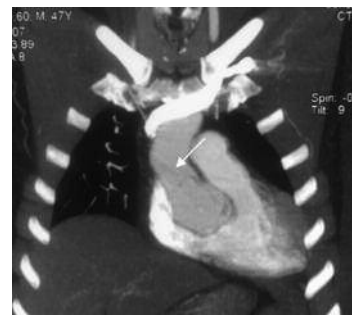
CT angiogram showing the dissecting flap.
